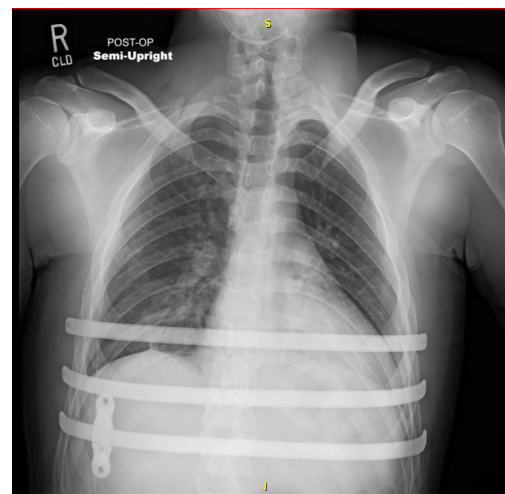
Anteroposterior chest X-ray of a patient with 3 bars in place to ensure proper correction of the deformity and medial stabilizer on the lower bar.
